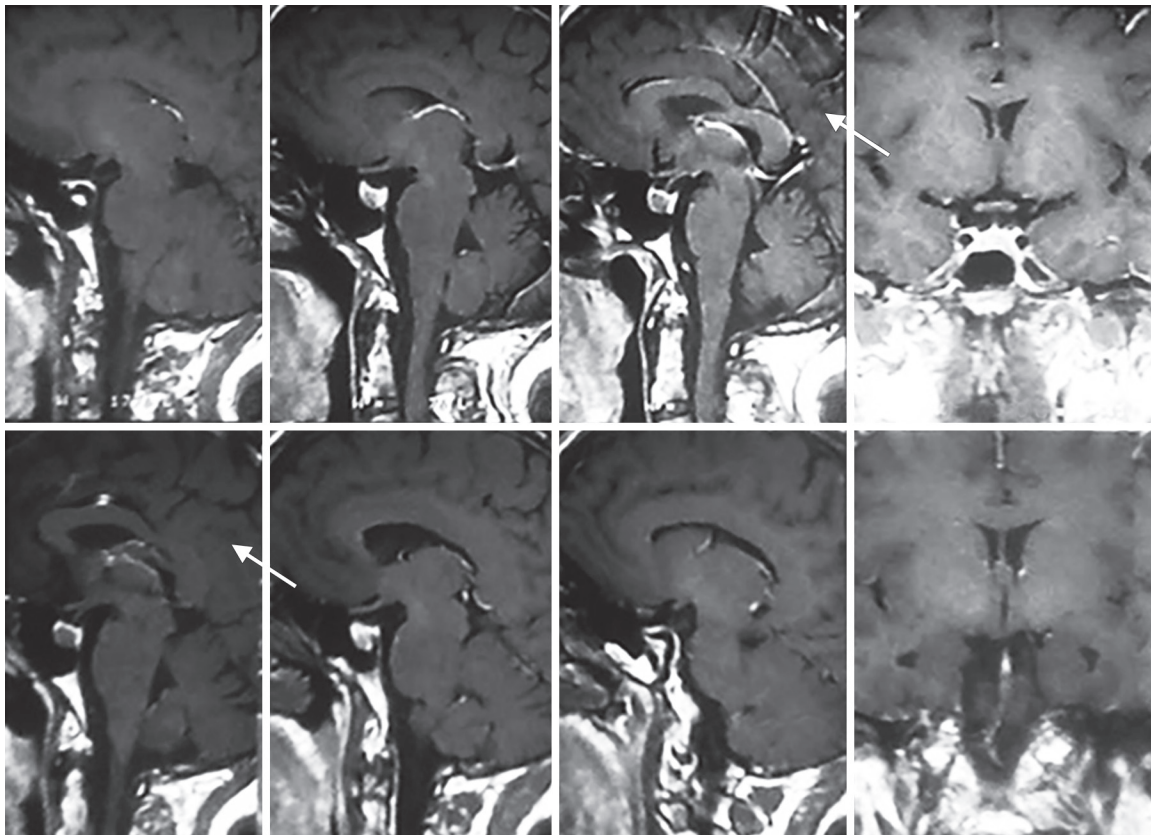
Sagittal (right) gadolinium-enhanced T1-weighted MRI images. There was a well-defined mass seen with the size of 12 × 8 mm in the center of pituitary gland without stalk shift that is not getting enhanced after injection of contrast agent. It is more likely to be Rathke cyst. Dynamic MRI is more accurate and recommended
